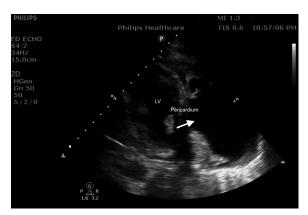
Echocardiogram parasternal short view showing large, well-circumscribed, anechoic structure was observed adjacent to the left pericardium (white arrow).
